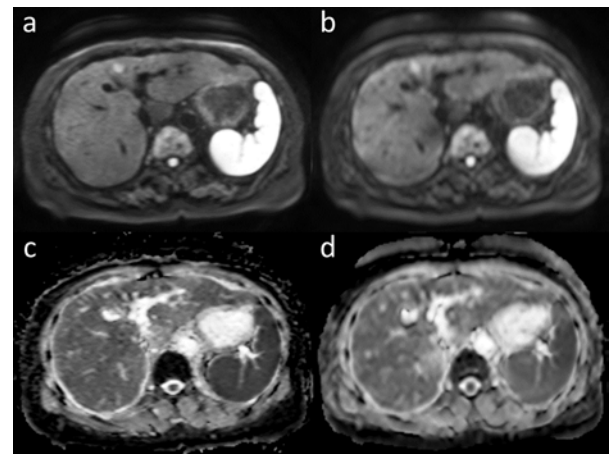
a) optimized DWI (b = 1,000 sec/mm<sup>2</sup>), b) conventional DWI (b = 1,000 sec/mm<sup>2</sup>), c) ADC map (optimized DWI) and d) ADC map (conventional DWI). The lesion in S4 of the liver showing hyperintensity on the optimized DWI is clearer than that on the conventional DWI.
